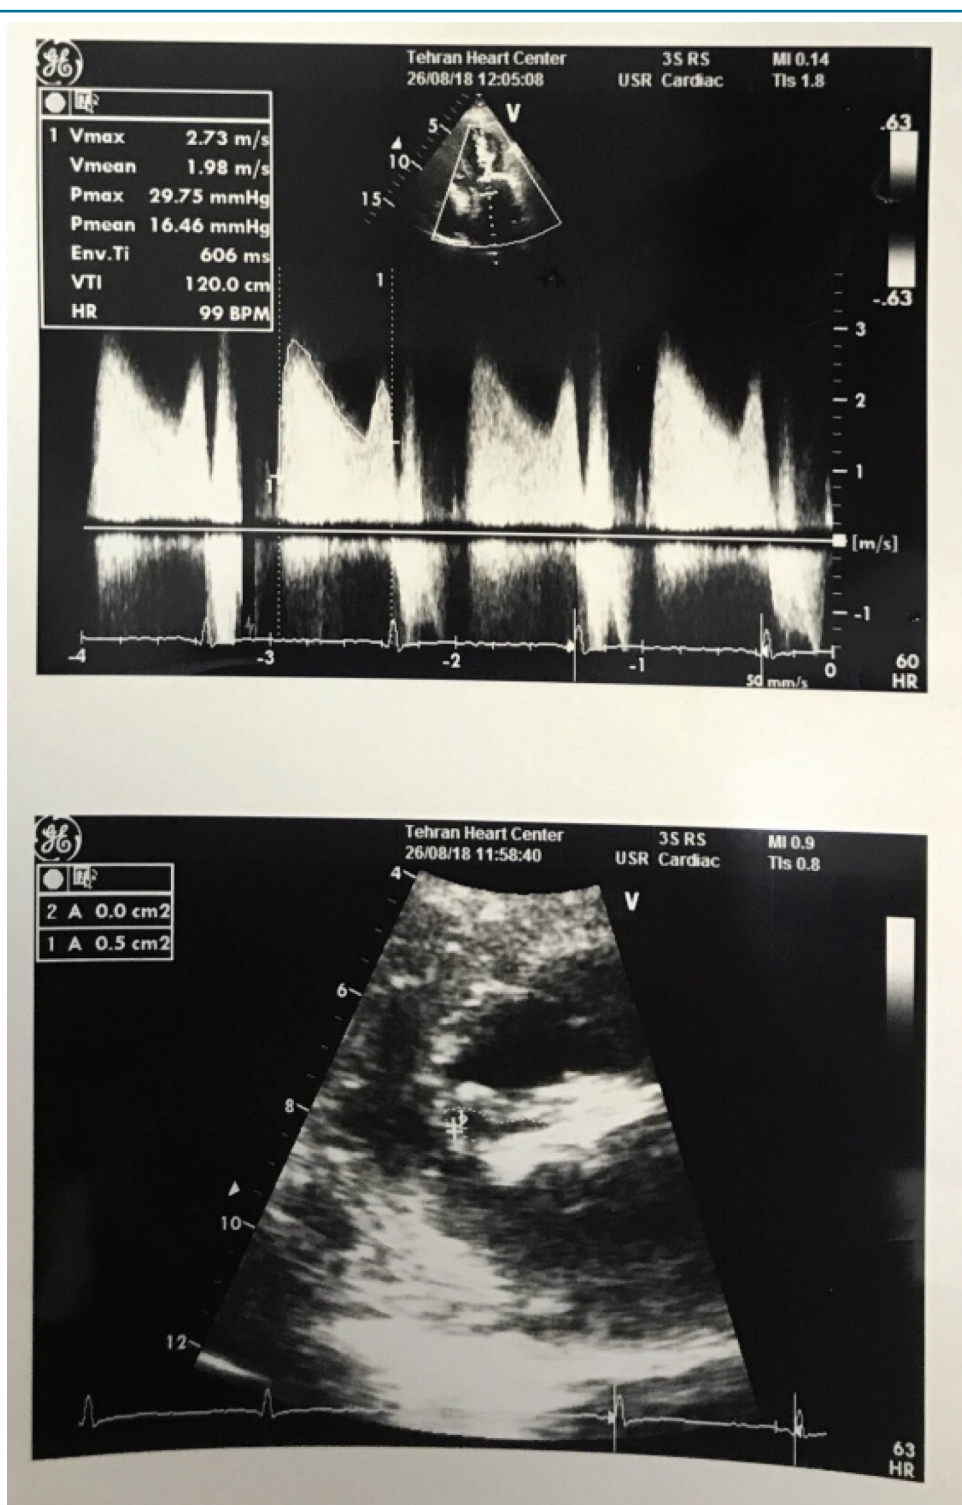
Upper figure: Echocardiography before mitral valve replacement. Ejection fraction of 60% with severe mitral stenosis (mitral valve area 0.5 cm², mean gradient 16 mmHg). Lower figure: Two-dimensional echocardiography showing mitral valve replacement with a St. Jude Medical Regent aortic prosthesis. Cross-section at the mitral valve, showing a calcified valve with a 0.5 cm² valve area by planimetry.
